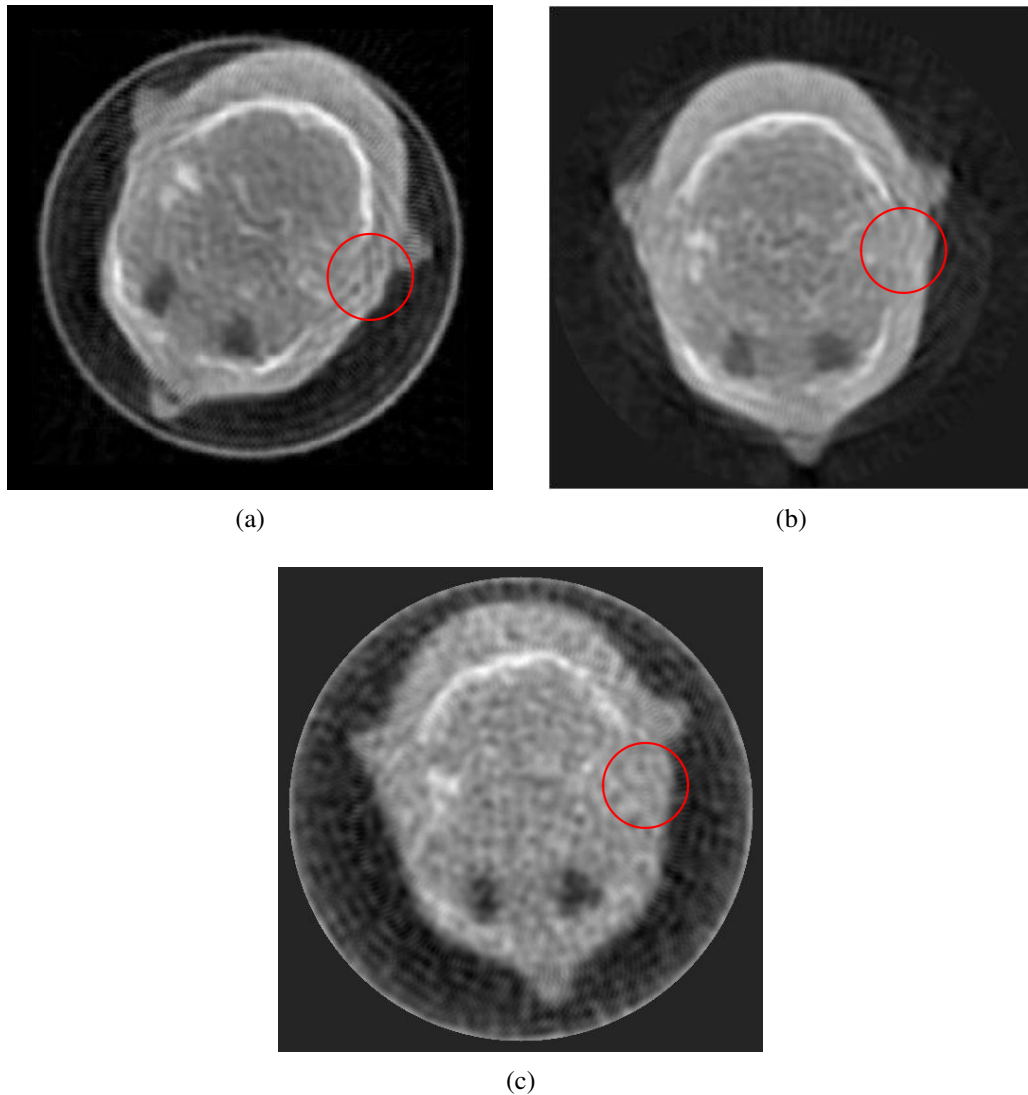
shows that the resulting image has less artifacts than the image obtained with the C-arm device (a) and that the contrast is better than in the image obtained from the mask detectors (b). Considering the drawbacks of the demonstrator (Sec. 3.4), the resulting image is remarkably good and demonstrates the potential of the CT d'Or. However, a lot of optimization still has to be done.
